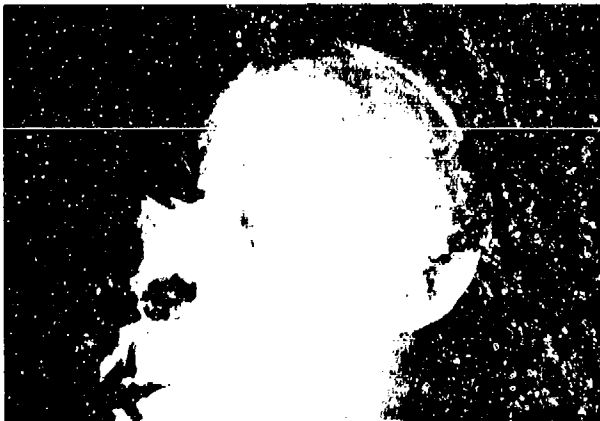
The casualty whose skull is shown in this roentgenogram was killed by an M43 ball fired from an AK47. The bullet broke up as it perforated the temporal bone and ricocheted after fracturing the opposite occipital bone. Note that a segment of the occipital bone has been detached from its surrounding tissue.
